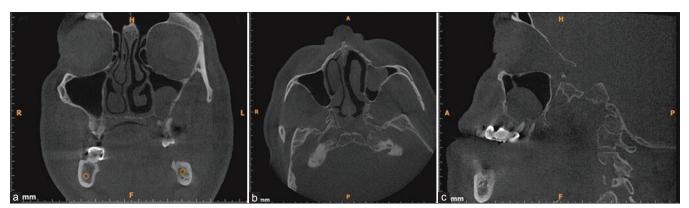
Cone-beam computed tomography scan showing polypoidal mucosal thickening in maxillary sinus. (a) Coronal section (b) axial section (c) sagittal section
